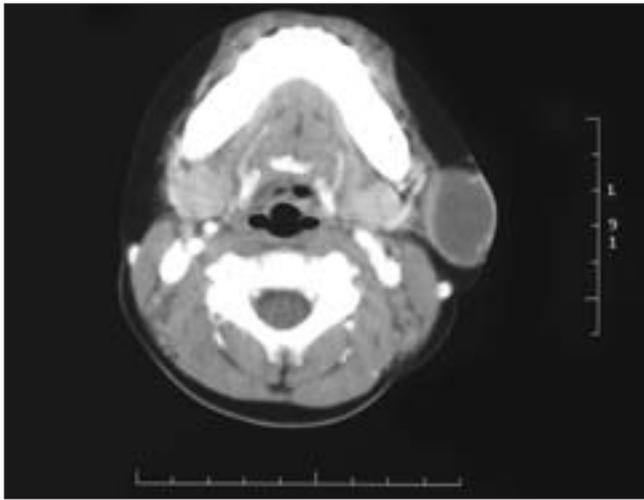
Computed tomography scan of the neck. A large, left-sided rim-enhancing node is present
